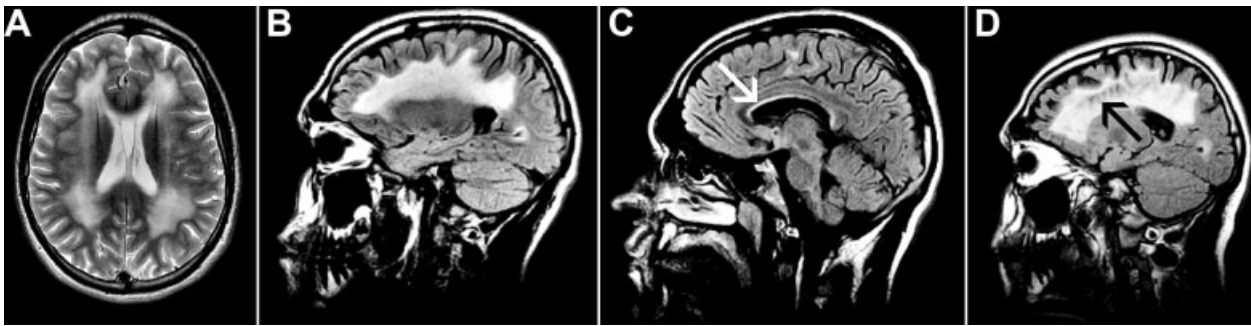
Early MRI in adolescent. Axial T₂-weighted (A) and sagittal FLAIR images (B, C) of patient 7 at age 15.8 years show signal abnormalities in the periventricular and bordering deep white matter and neither delayed myelination nor atrophy. The inner rim of the corpus callosum is affected (C, arrow). At age 19.3 years, sagittal FLAIR image (D) shows more extensive abnormalities and rarefaction of the white matter (arrow).
